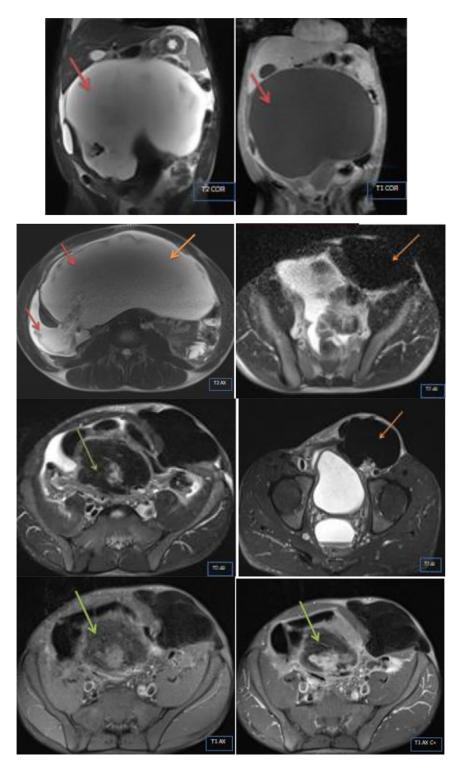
MRI in axial T2-weighted, coronal T2-weighted with fat saturation, and T1-weighted sequences with and without contrast injection reveals a sizable intra-abdominal mass occupying almost the entire abdomen, extending to the mesenteric root, displacing the loops and the liver, coming into contact with the aorta and iliac pedicle. This mass exhibits a dual cystic component, with hypointensity on T1 and hyperintensity on T2 (red arrow) for the cystic part, and hypointensity on T2 with heterogeneous enhancement postinjection for the solid tissue component (green arrow), measuring 14 x 16 cm. Additionally, there is another inguinal mass (orange arrow) with marked hypointensity on T2 and weak enhancement on T1 postinjection, measuring 106 x 82 x 176mm, without significant diffusion restriction. Moderate ascites is present.
